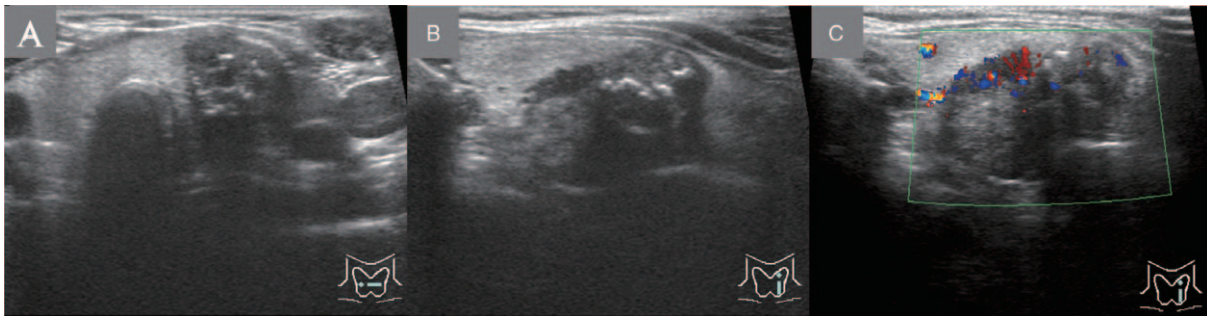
Neck ultrasonogram. (A) The cross-section showed that part of the trachea was surrounded by a solid mass; (B) the longitudinal section showed a solid mass with calcifications on the middle and lower part of the left lobe of the thyroid gland; (C) the longitudinal section showed that the mass had a second-degree blood supply.
